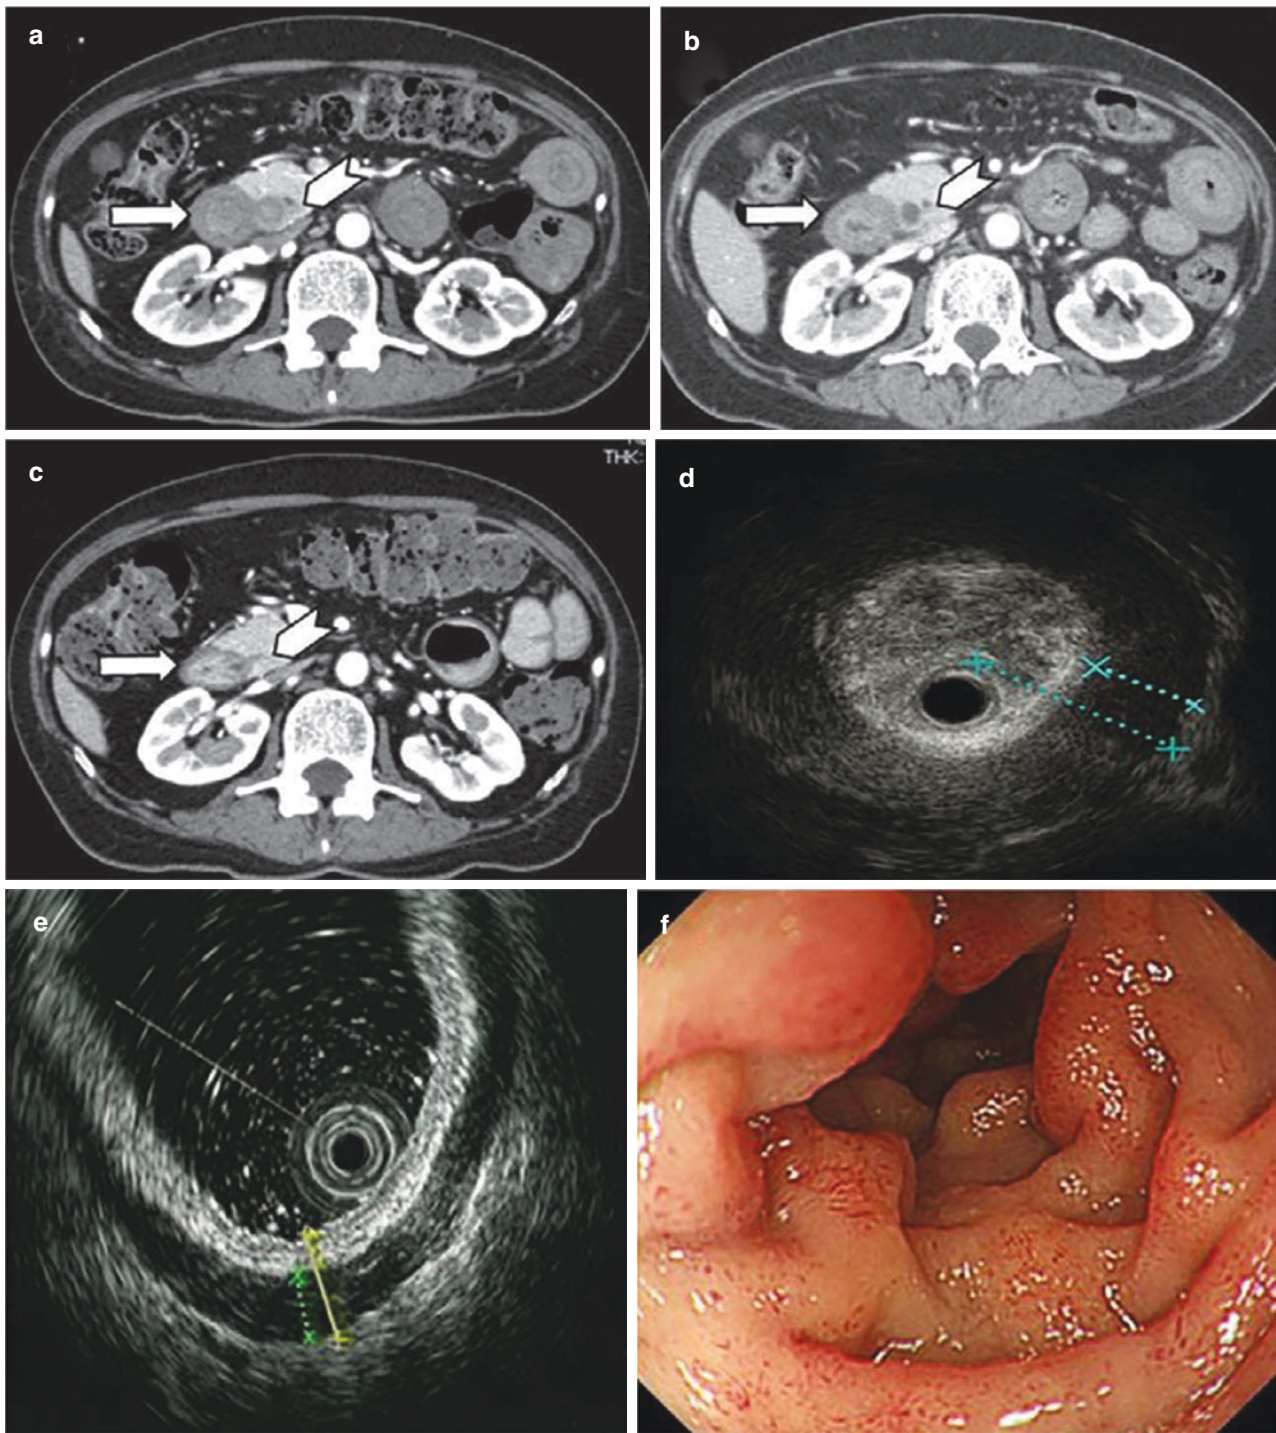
(a–h) Contrast-enhanced computed tomography (CT) findings (a–c) and endoscopic ultrasound (EUS) findings of the duodenum (d–e). Upper gastrointestinal endoscopic examination findings (f–h). (a, b) CT revealed the thickening of the gastroduodenal mucosal wall (arrow). (d) EUS of the duodenum revealed extreme thickening of the mucosal and muscular walls. (c, e) Both findings were improved after
